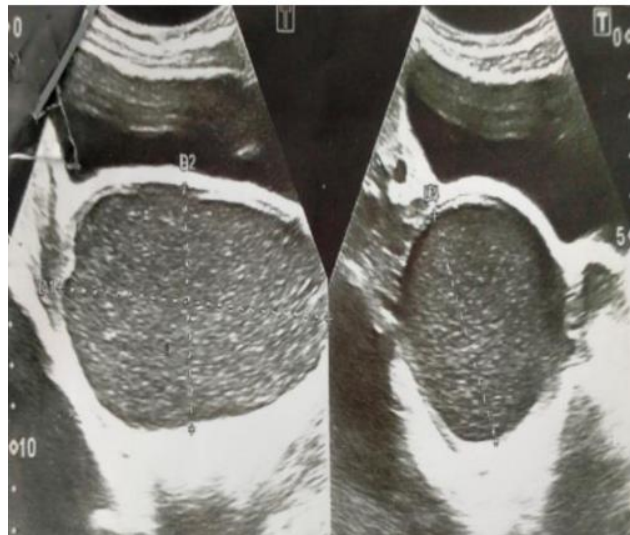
Pelvic ultrasonography revealed hematocolpos
